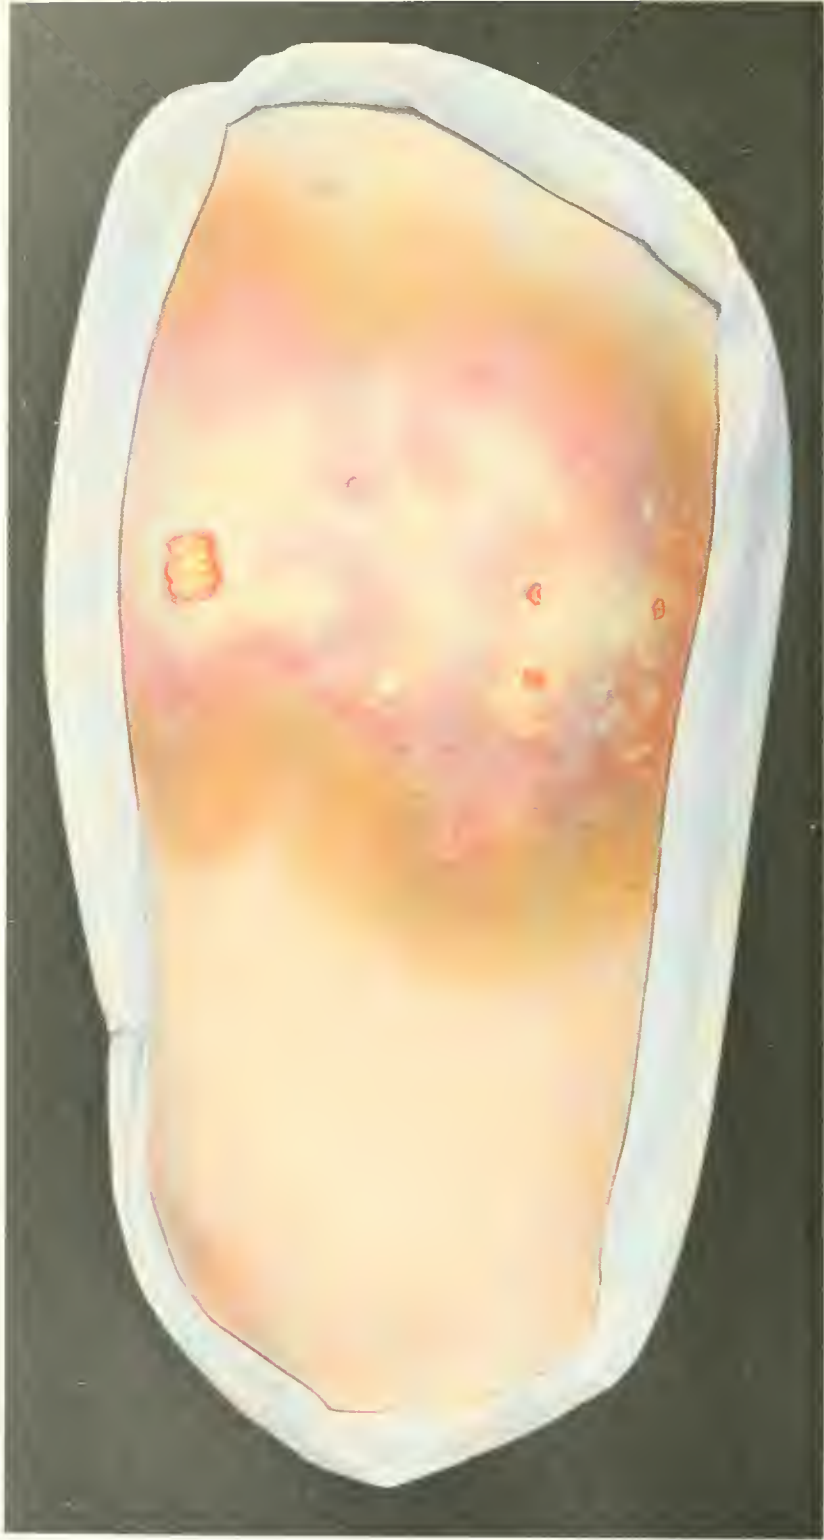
Combustio (X-Rays).
